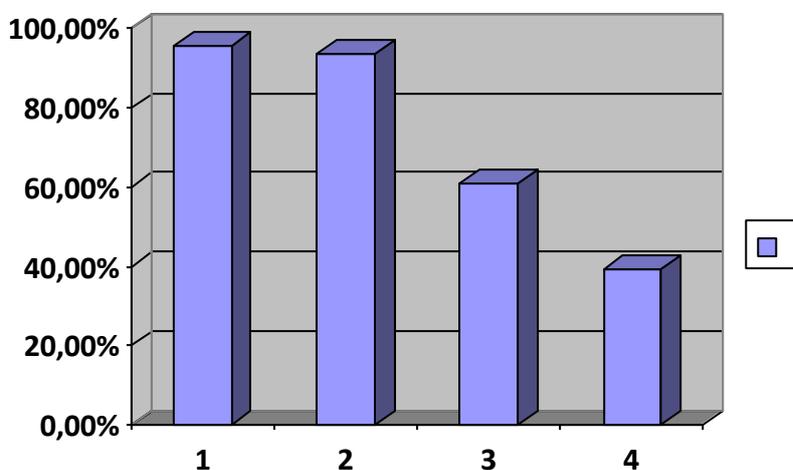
The distribution of the various imaging modalities prescribed by the respondents. 1. periapical radiography; 2. OPG; 3. CBCT; 4. bitewing radiography.
